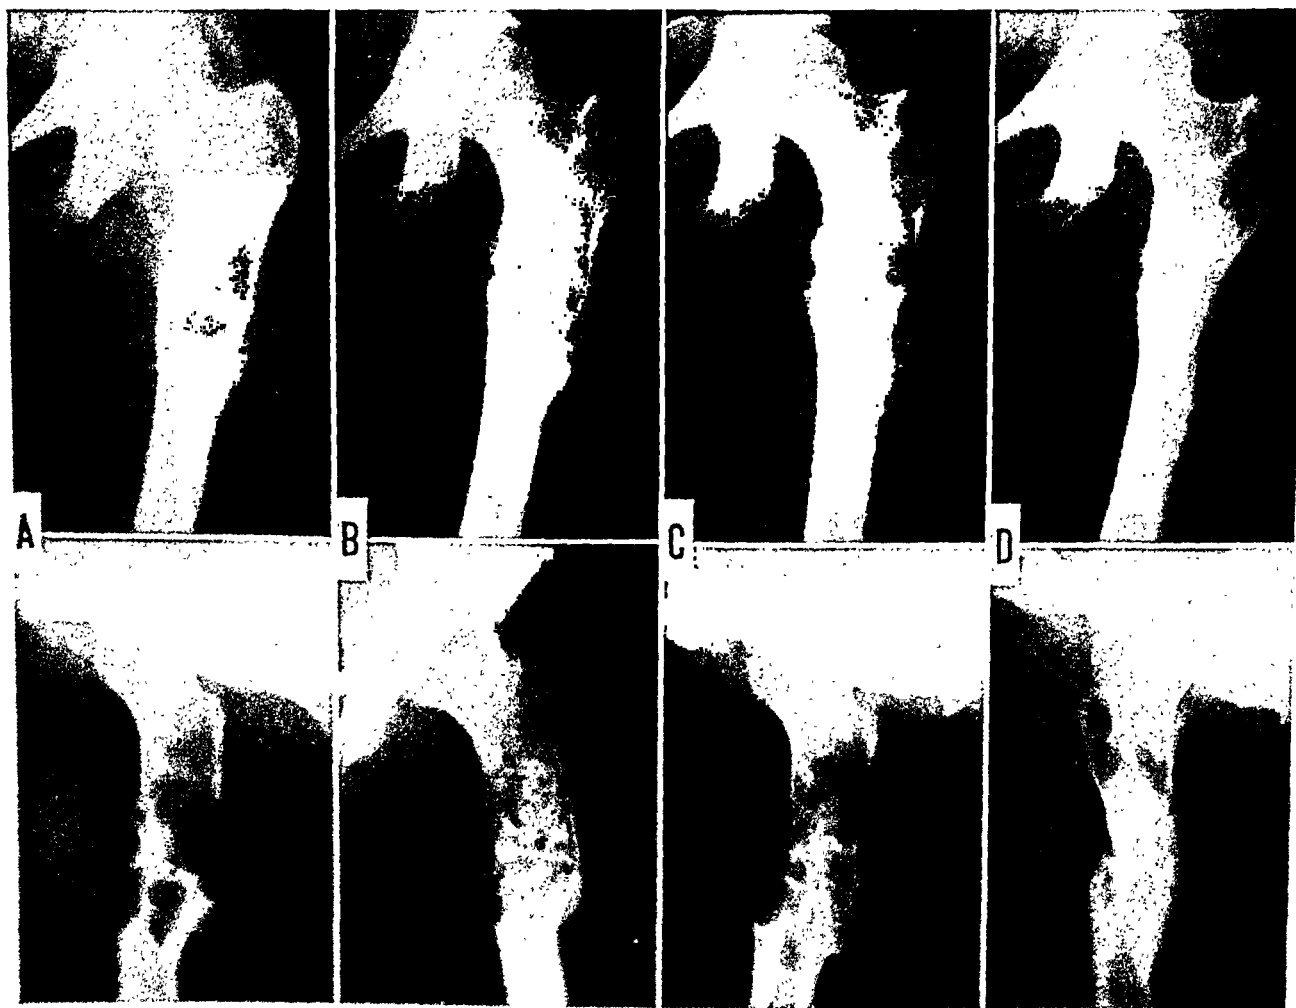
Case VIII. *A*, multilocular cyst of the upper end of the left femur; *B*, after curettage and filling of cavity with bone chips; *C*, one year later, showing malignant metaplasia; *D*, five years later (three years after roentgen therapy) showing satisfactory result.
